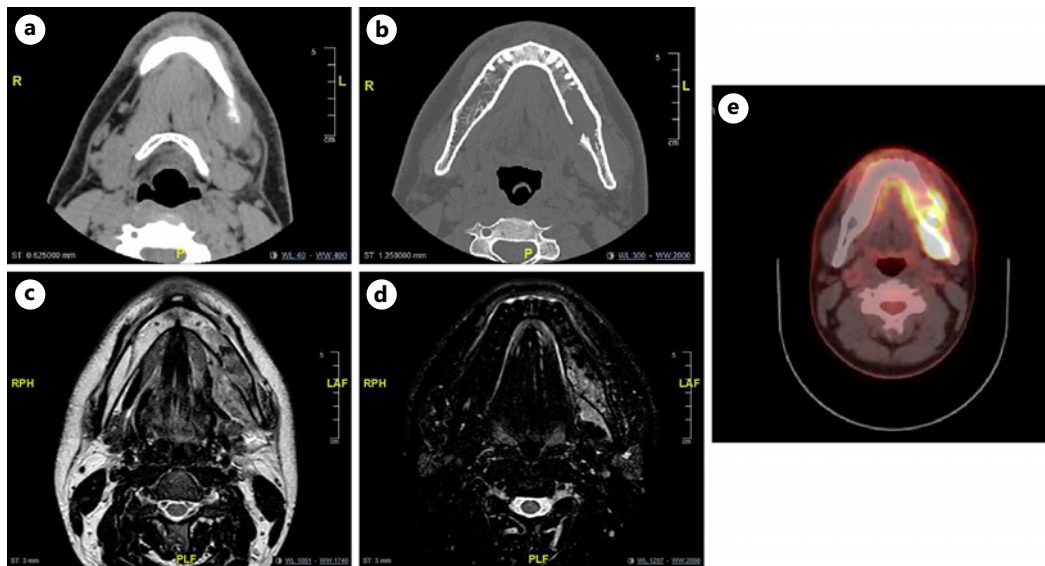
a CT of the facial region with the bone window. b CT of the facial region with the soft tissue window. c MRI facial region showing enhancement. d MRI facial T2 with fat suppression. e PET scan with FDG uptake. MRI, magnetic resonance imaging; PET, positron emission tomography.
